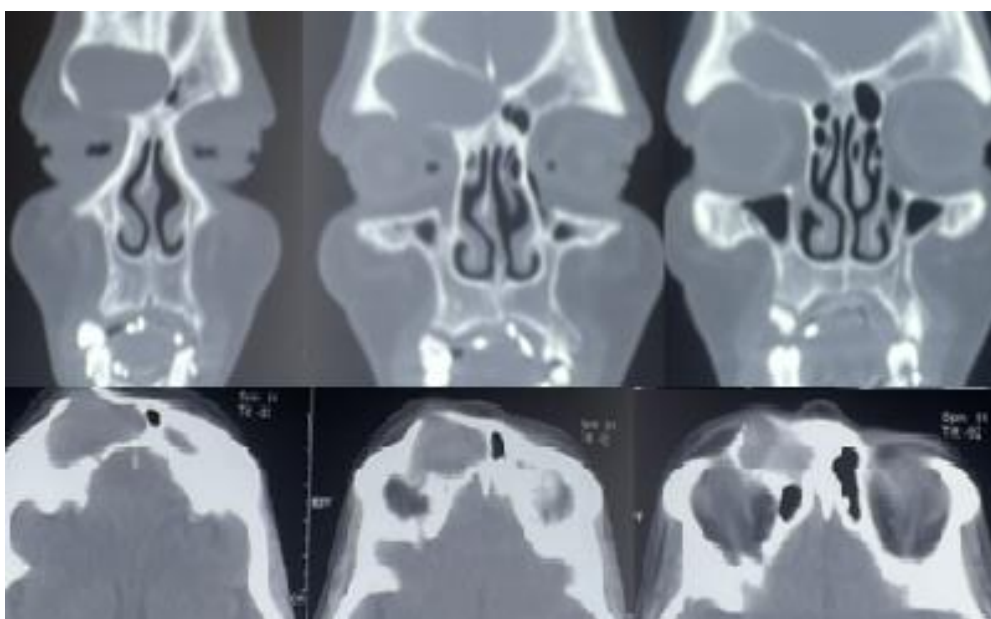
CT (axial and coronal images): right frontal mucocele with intraorbital extension and elevation of the overlying soft tissues
